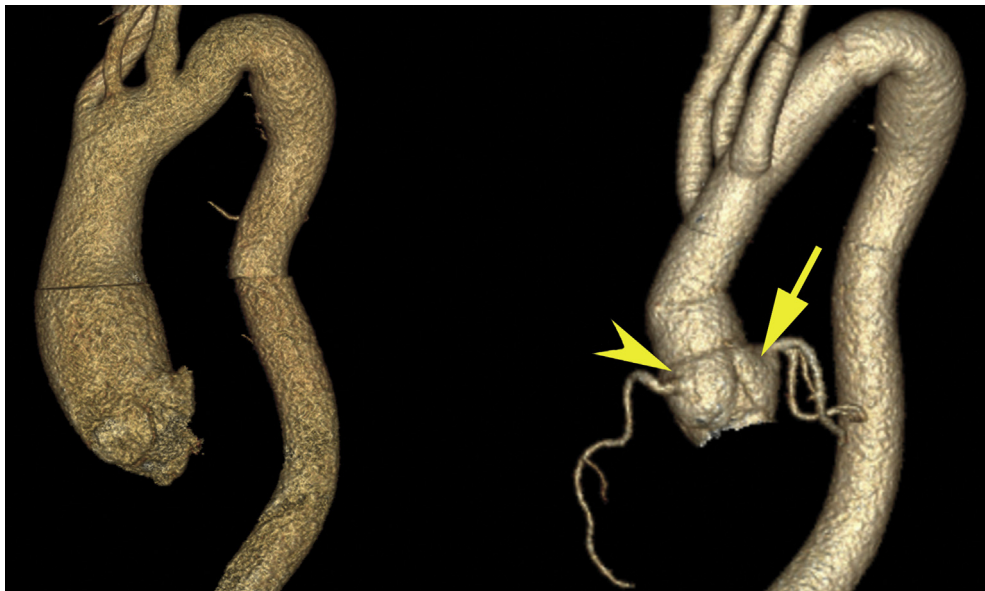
Preoperative and postoperative 3-dimensional volume rendering technique reconstructions of contrast-enhanced computed tomography scans (computed tomography angiography) of 52-year-old woman with confirmed diagnosis of Marfan syndrome who received patient-tailored aortic root repair with replacement of noncoronary and right coronary (marked with *arrowhead*) sinus, leaving the left coronary sinus (marked with *arrow*) untouched. A total arch replacement was performed concomitantly because the patient presented with dissection history of abdominal aorta and positive familial history.
